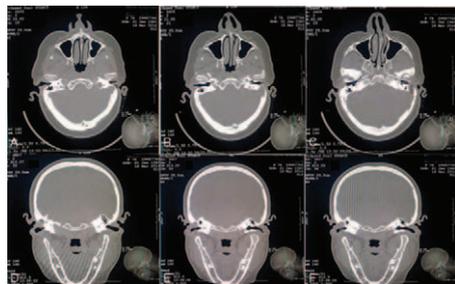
First row: axial CT scan series of the temporal bone from bottom to top. A, Very thin bone plate of temporal bone covering the sigmoid sinus on the left temporal bone (black open arrows). B, Absence of bony plate. Note that mastoid portion of the temporal bone is rudimentary (white open arrows). C, The sinus is in direct contact with the posterior–superior region of the external ear canal skin (white arrow: external ear canal, black arrow: sigmoid sinus hanging to external ear canal). Second row: coronal CT scan series of the temporal bone from posterior to anterior. D, Intratemporal course of the sigmoid sinus is clearly seen (black asterix: sigmoid sinus, white asterix: antrum surrounded by periantral hair cells) E, Absence of bony plate just inferior to the sigmoid sinus (black asterix: sigmoid sinus, white asterix: antrum mastoideum). F, Hanging sigmoid sinus to the superior portion of the external ear canal (white open arrows). CT, computed tomography.
